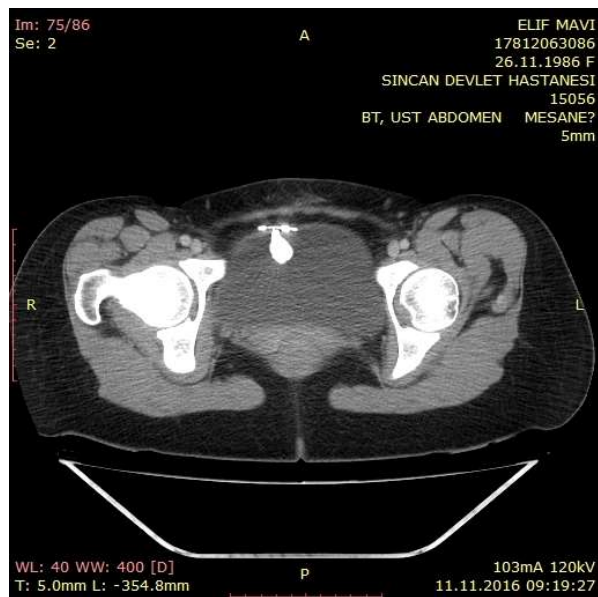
CT image of calcified IUD.
